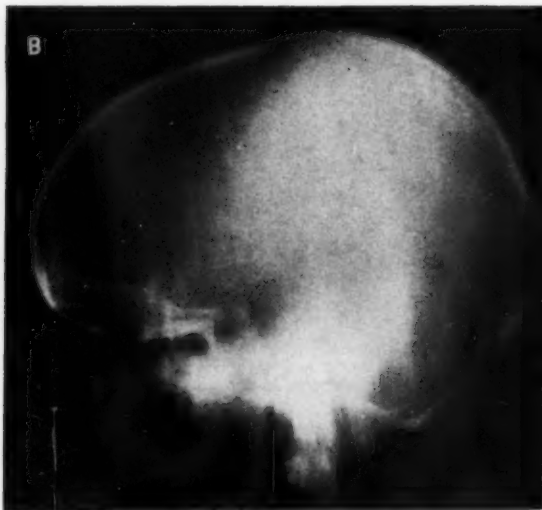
Case 3. A. Lateral roentgenogram centering on the nasopharynx. No pathologic changes are visible. B. Lateral midline laminagram, revealing sclerotic changes in the antero-inferior aspect of the sphenoid. C. Basilar view showing destruction in the region of the right lacerated foramen.
